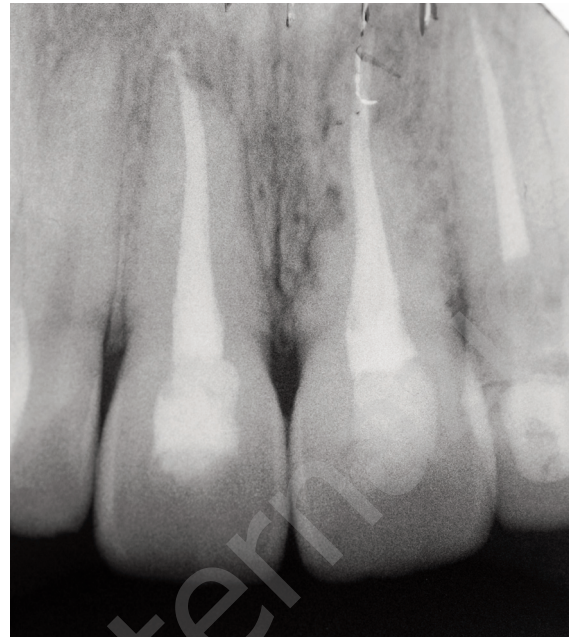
Periapical radiograph at 2 years recall visit.
